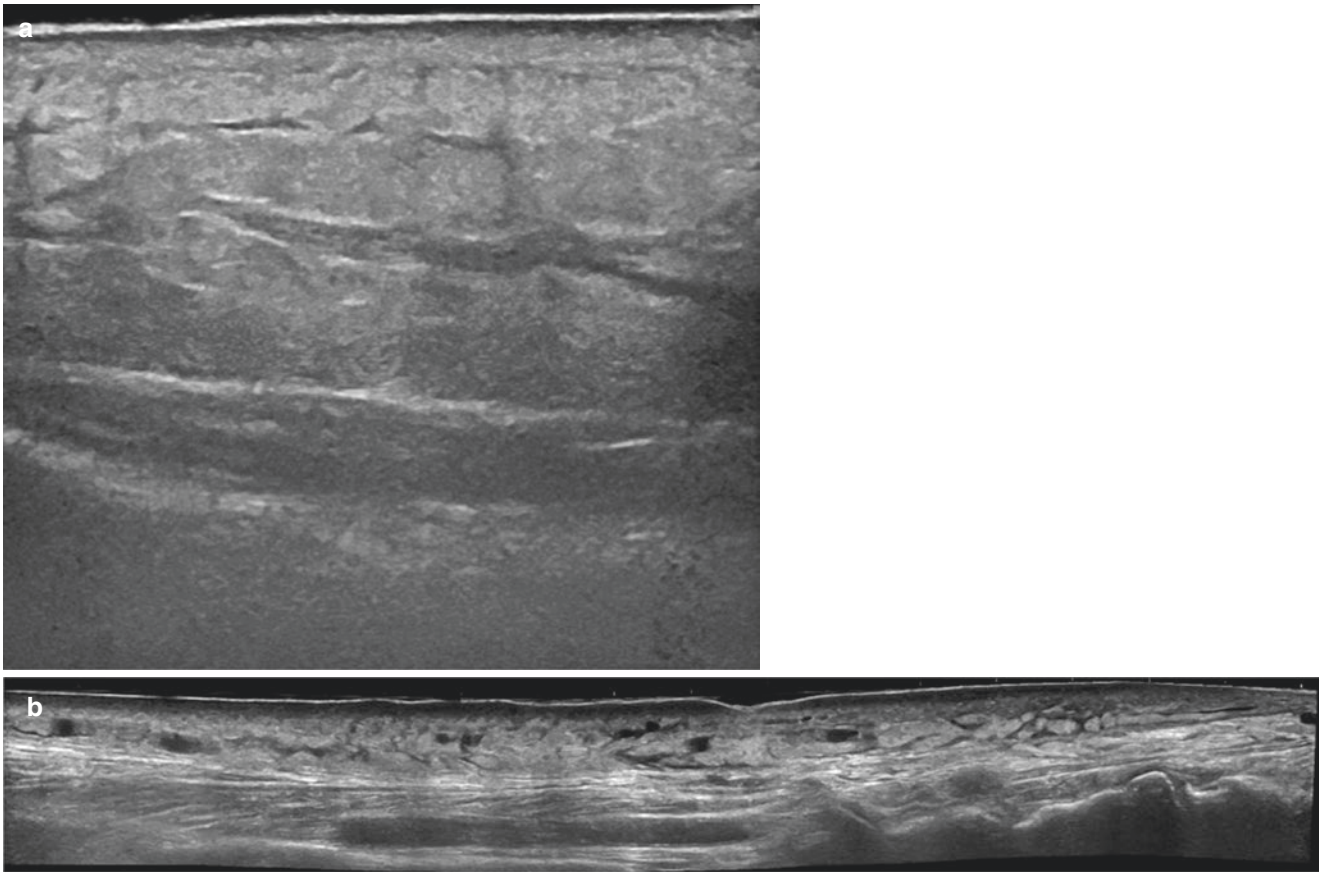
Lymphedema. (a, b) Ultrasound (greyscale) shows thickening of the epidermis, dermis, and hypodermis. There is hypoechogenicity of the dermis and hyperechogenicity of the hypodermis. In (a) notice that the fluid between the fatty lobules may present higher echogenicity than with plain edema.
